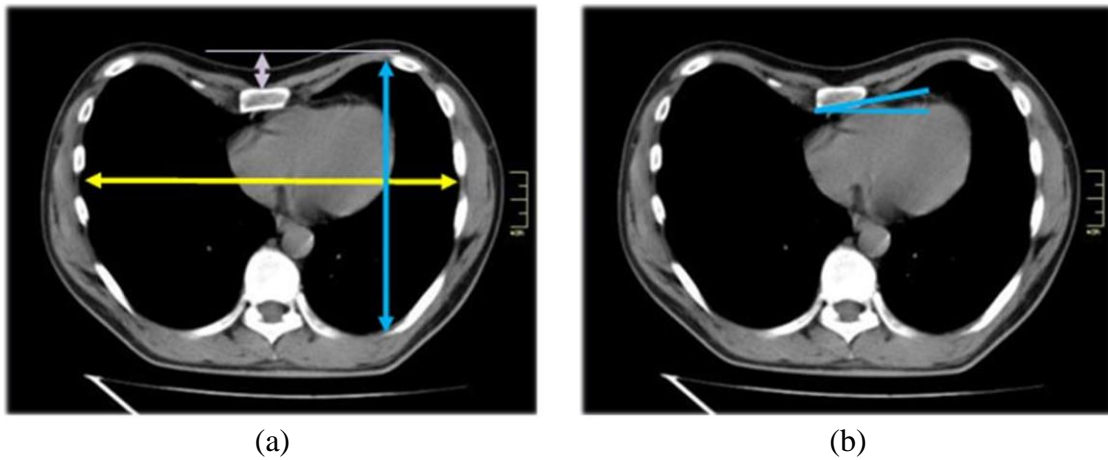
CT measurements: (a) width, depth, depression, (b) sternal torsion
